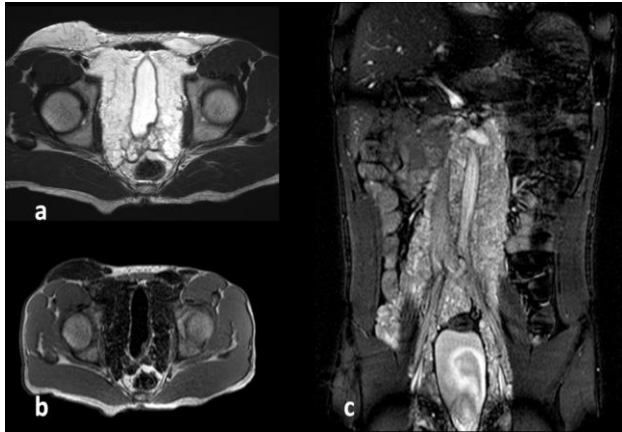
(a) MRI of abdomen and pelvis in axial reconstruction showing T2 hyperintense, (b) T1 hypointense, (c) lesion in pelvis in perivesical region and in right inguinal region. Short TI Inversion Recovery (STIR) coronal image showing hyperintense cystic lesion in retroperitoneum.
